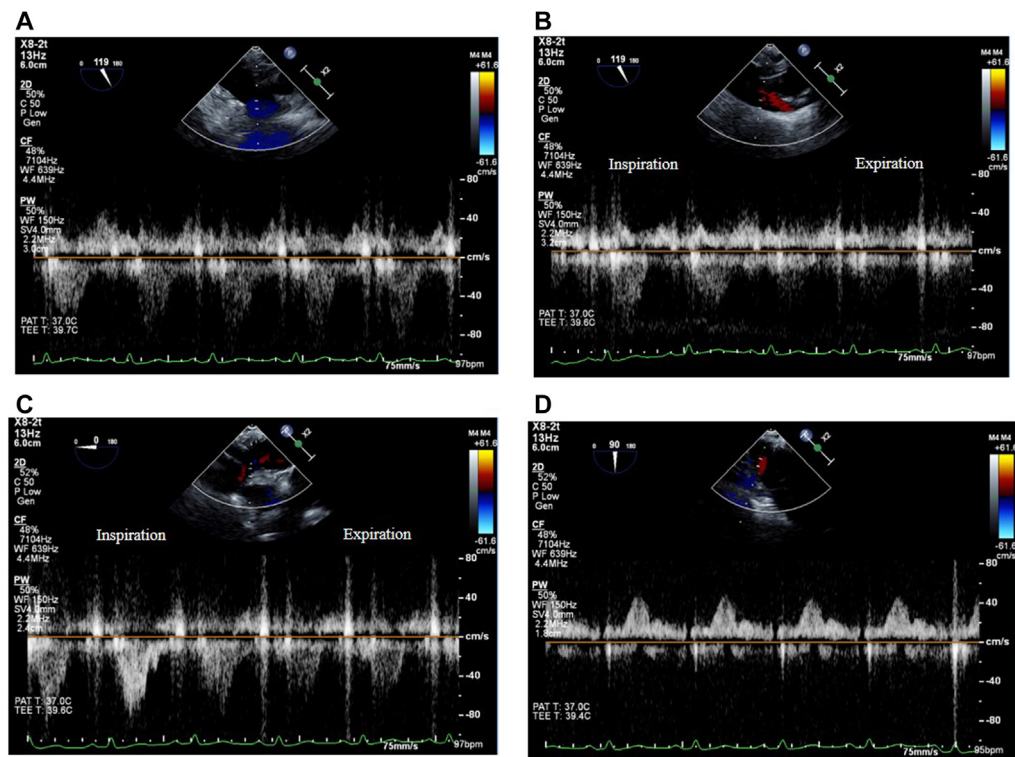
Two-dimensional TEE, midesophageal long-axis (119°) view with color-flow Doppler-guided pulsed-wave Doppler, demonstrates (A) systolic flow reversal in the right upper PV spectral Doppler display that changes during respiration and is mostly seen during inspiration (B); long-axis (0° and 90°) views demonstrate inspiratory systolic flow reversal in the right lower PV (C) and normal antegrade systolic flow (D) in the left upper PV.
